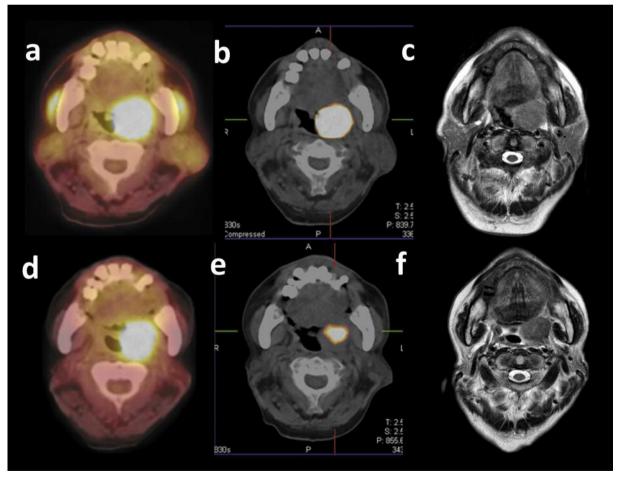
Case1: A 62-year-old male with oropharynx cancer (T3N0M0) with strong FMISO accumulation at the first examination. a: FDG PET/CT before RT. b: FMISO PET/CT before RT. c: MRI before RT. d: FDG PET/CT after RT. e: FMISO PET/CT during RT. f: MRI after RT.
